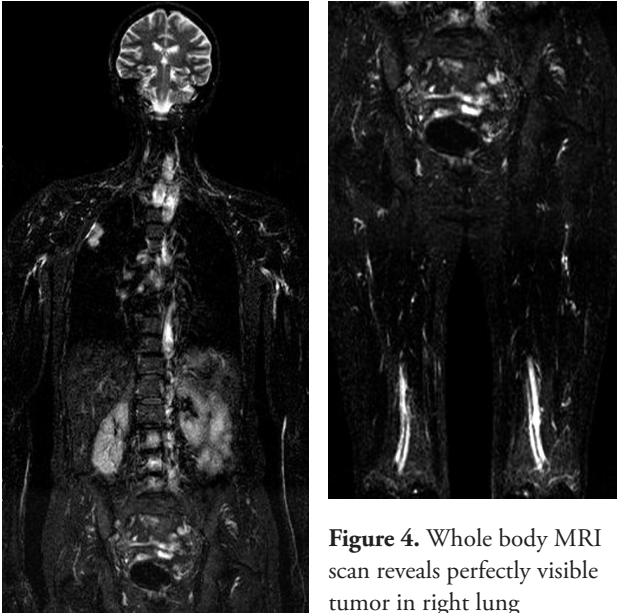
Whole body MRI scan reveals perfectly visible tumor in right lung
